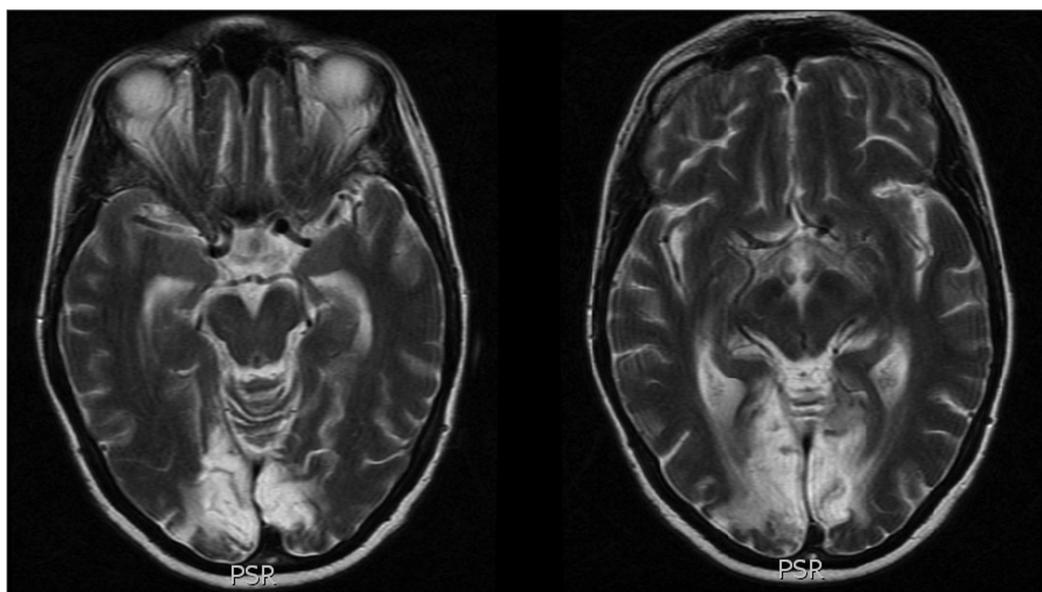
MRI of 12-2009 showing increased T2 signal in both occipital lobes.
